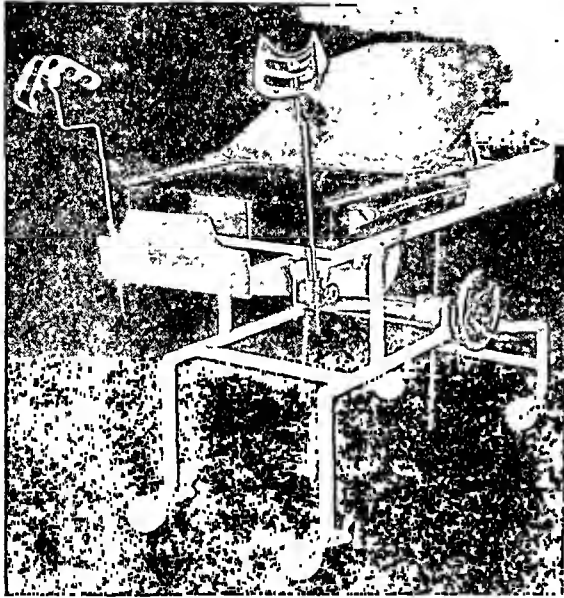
Cystoscopic roentgen-ray table.
